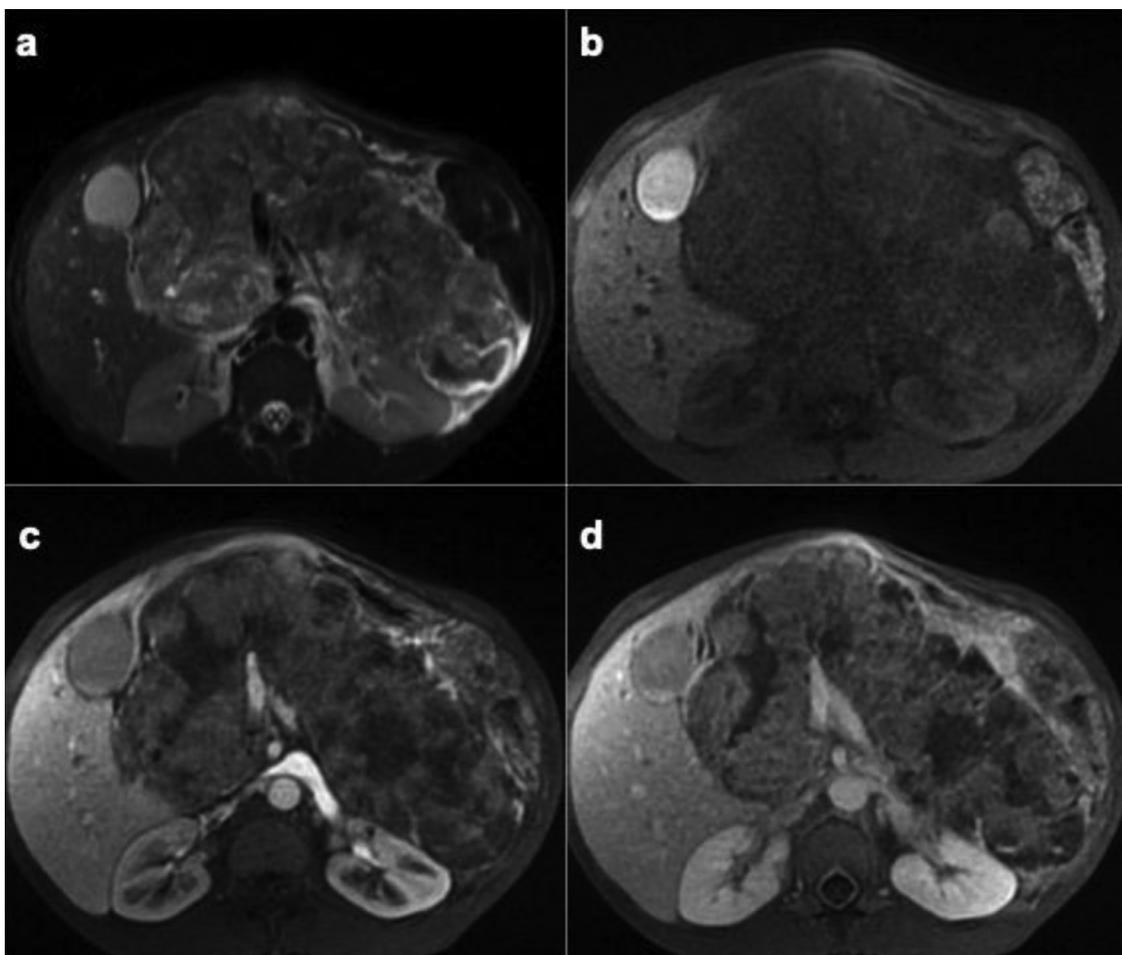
Pancreatoblastoma in a 29-year-old female patient. Fat-suppressed T2-weighted MR image (a) shows a large heterogeneous mass in the entire pancreas. Precontrast (b) fat-suppressed T1 GRE MR image shows that the lesion is heterogeneous with hyperintense foci. Contrast-enhanced fat-suppressed T1 GRE MR images obtained during the arterial (c) and portal phases (d) show the heterogeneous and mild enhancement of the lesion, with hypointense necrotic intratumoral changes.
